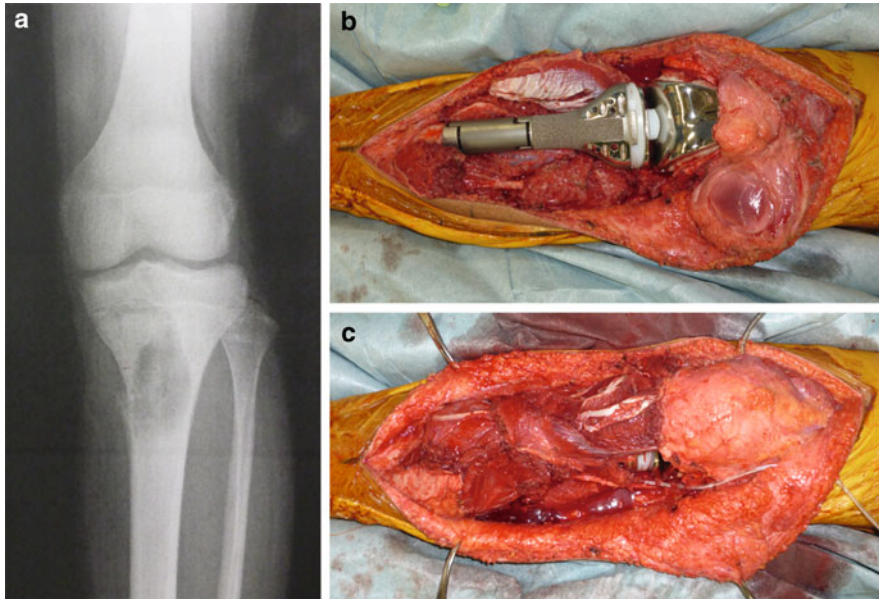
Application of a gastrocnemius flap in the reconstruction of the proximal tibia in osteosarcoma. (a) Radiographs at presentation, (b) a wide resection of the proximal tibia followed by endoprosthetic reconstruction in a 16-year-old boy with osteosarcoma, and (c) gastrocnemius flap application with blood flow from the posterior tibia vessels
